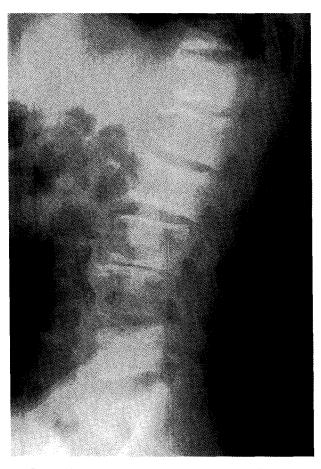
Lateral lumbar radiograph demonstrated sclerotic changes in most of the lumbar spines.
